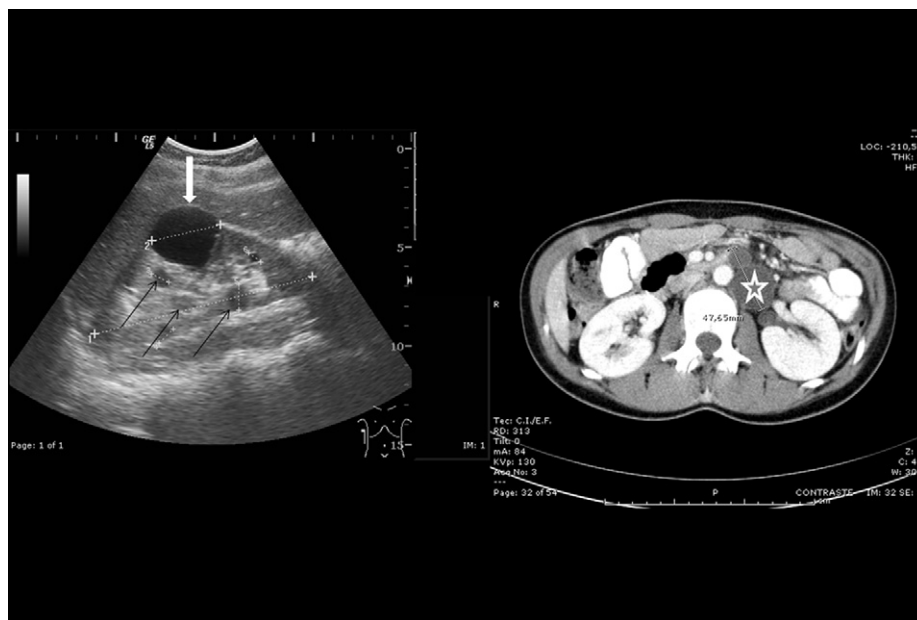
Renal ultrasonound scan of the younger sibling shows multiple renal cysts (black arrows for the small cysts and white arrow for the biggest cyst), and abdominal CT scan of the older sibling revealing intestinal duplication cyst (star). Abbreviation: CT = Computed tomography.
